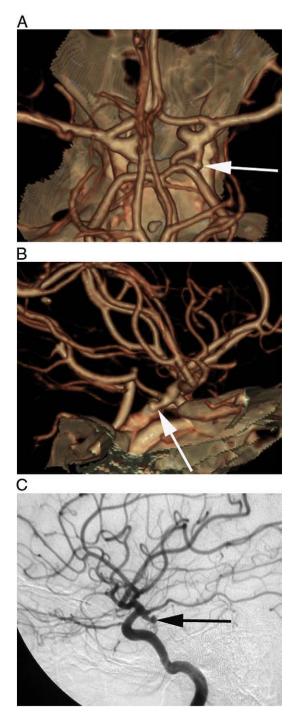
Left PCoA aneurysm in a 55-year–old woman with SAH. The VR (A) images from CTA do not clearly display the left PCoA aneurysm (arrow). The primary reason for the missed aneurysm seemed to be the close proximity to bone. When CTA images are viewed retrospectively, the missed aneurysm is visible on the VR (B) images (arrow). The DSA (C) image clearly shows the aneurysm (arrow).
